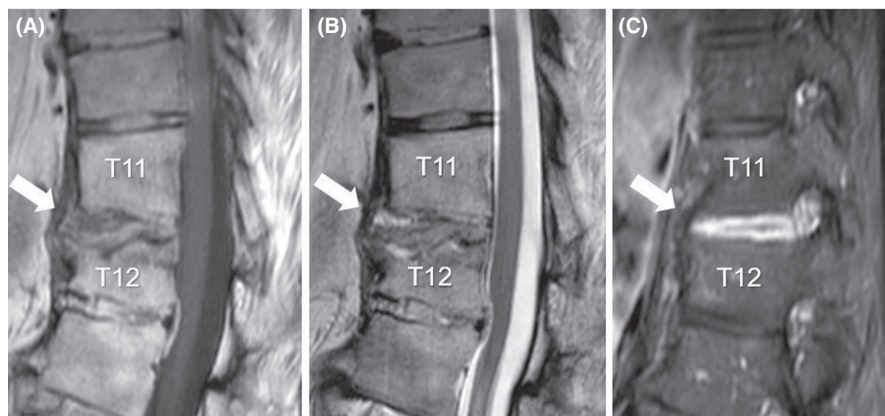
Sagittal MRI of the thoracolumbar junction at the initial visit to our department: (A) T1-weighted image, (B) T2-weighted image, and (C) gadolinium-enhanced T1-weighted image. The arrows indicate continuity of anterior segment between T11 and T12 vertebral body.
